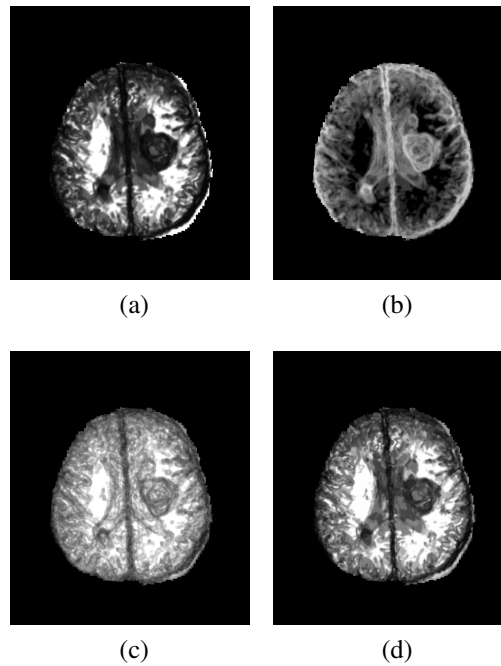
Highlight features extracted from an active (a) FLAIR image yielding (b) Sobel image, (c) Enhanced image and (d) Hyperintensity map.
